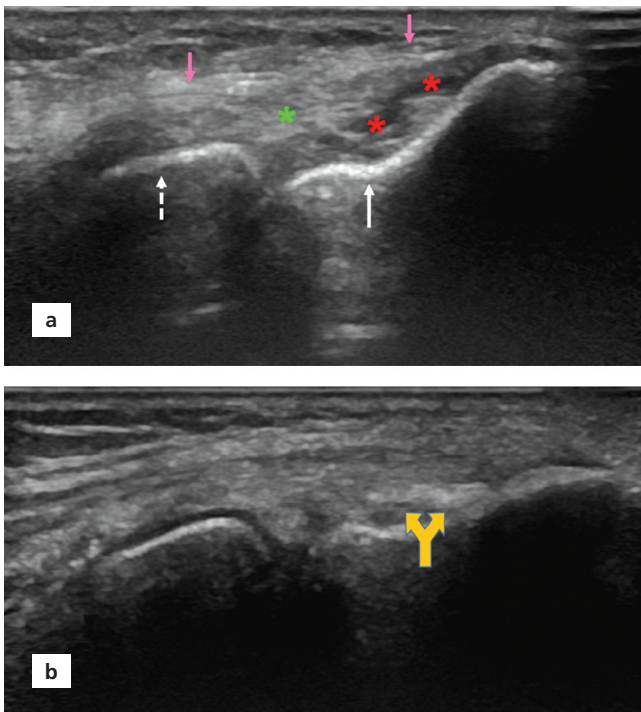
B-mode ultrasonography of lateral epicondyle (white arrow), distal radius (dashed white arrow), common extensor tendon (green asterisk) and upper border of the tendon (pink arrows). (a) intratendinous partial rupture (red asterisks) (b) intratendinous calcification (double-headed arrow).
